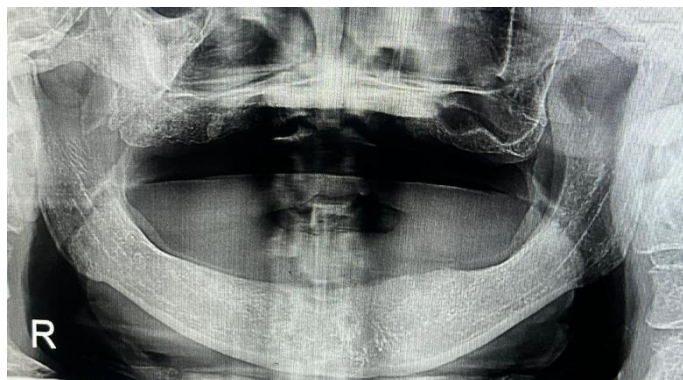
Panoramic radiograph obtained one month after alveoloplasty.
